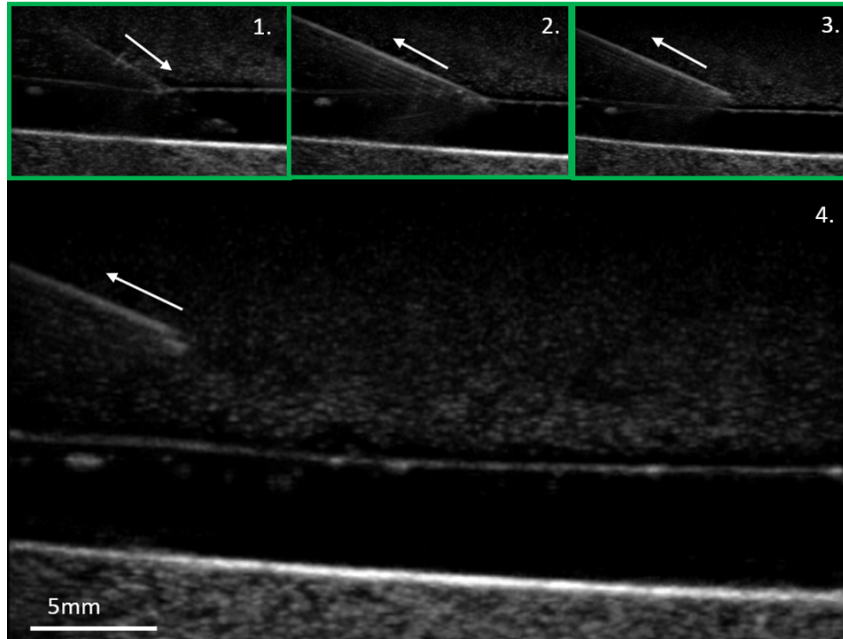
Vascular puncture leaves minimal damage to vessel structure. Ultrasound images show 22G needle puncturing vessel (1) and subsequent removal (2-4)
